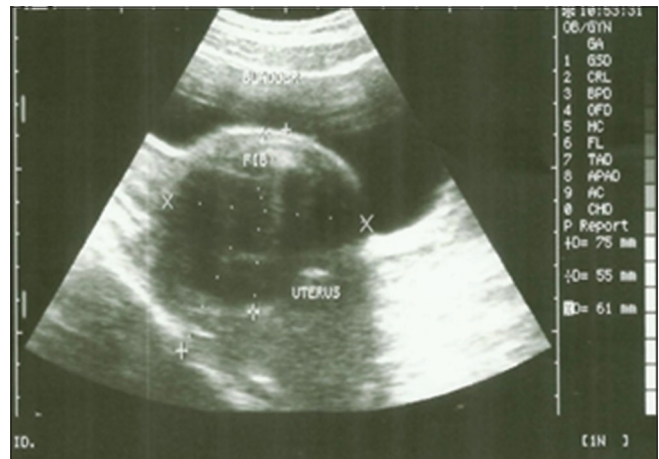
Longitudinal ultrasound scan showing the bladder, uterus, and fibroid (fib). The fibroid was identified as an oval echopenic mass
